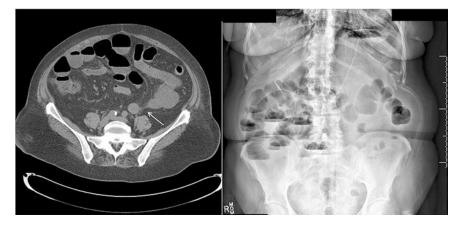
Radiographic images of a patient with partial small bowel obstruction after abdominal sacral colpopexy. The CT scan (*right*) shows distended loops of bowel with a transition point marked with an *arrow*
